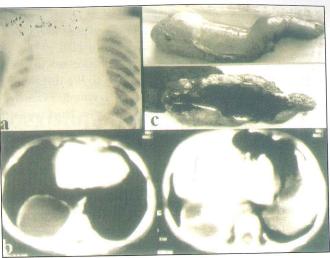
Chest X-ray and tomography showing a right posterior mediastinal cystic mass encircling the diaphragm in case 2 (a-b) and the surgically excised mass containing a meconium like liquid (c).
